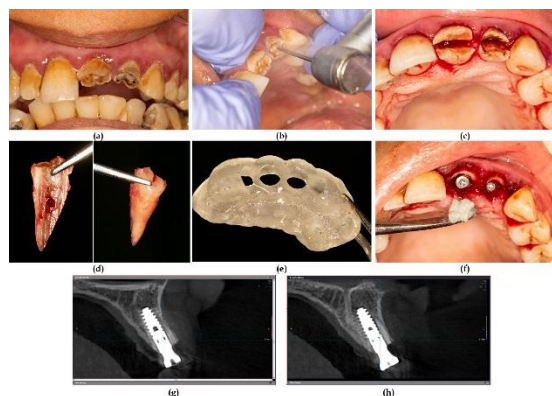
(a) Preoperative image. (b), (c) Socket shield preparation. (d) Removal of the palatal portion of the tooth. (e) Surgical guide printed. (f) Placement of the dentin graft after implant placement. (g), (h) cross-sectional view of cone-beam computed tomography images.
